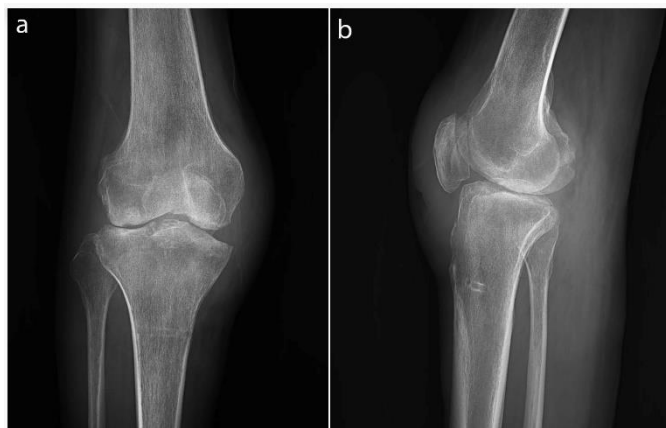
Anteroposterior (a) and lateral (b) radiographs of the knee one year after the operation
